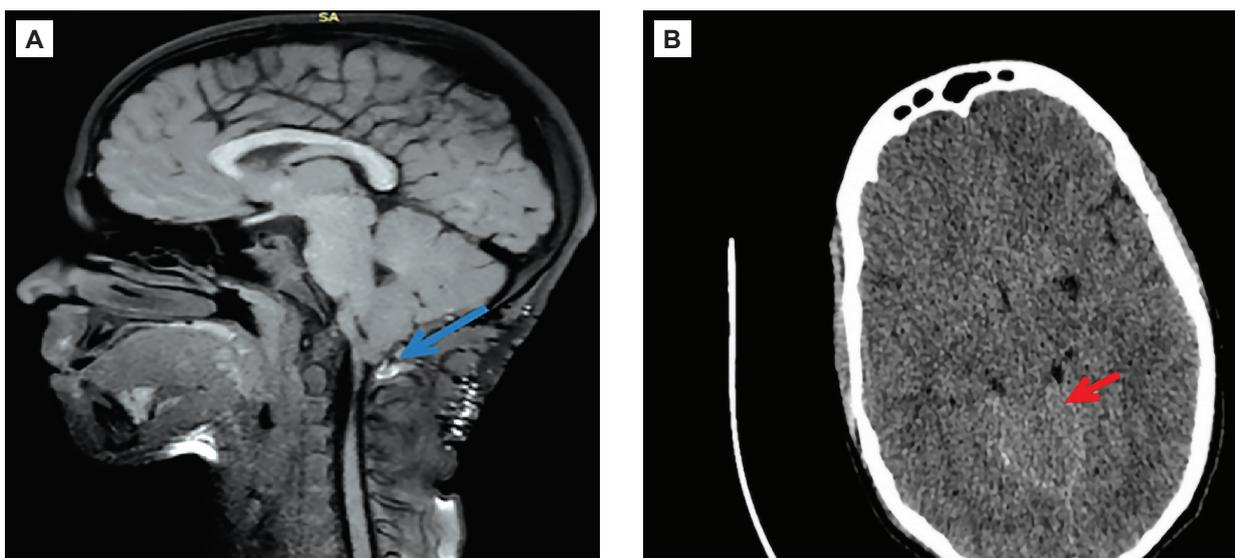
a) A sagittal T1-weighted MRI image is shown. The tonsils are shown to be drooping. Note the blue arrow. b) Axial CT image shows compression of the posterior cranial fossa structures due to the descent of the cerebellar tonsils
